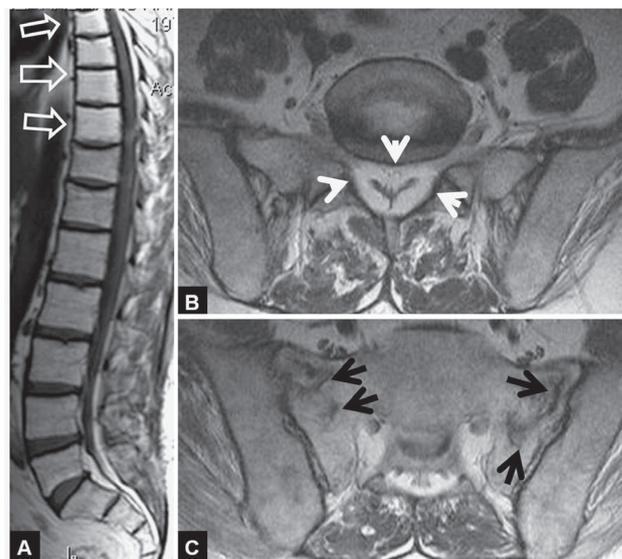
A 32-year-old patient with a history of advanced low grade non-Hodgkin lymphoma involving the T-spine. Treatment included radiotherapy and steroid administration. Sagittal T1w (A) and axial T1w (B, C) MR images showing myeloid depletion and fatty replacement at the level of the irradiation (white open arrows), epidural lipomatosis with the typical “Y” configuration of the dural sac at L5/S1 (white arrowheads) and insufficiency sacral fractures (black arrows).
